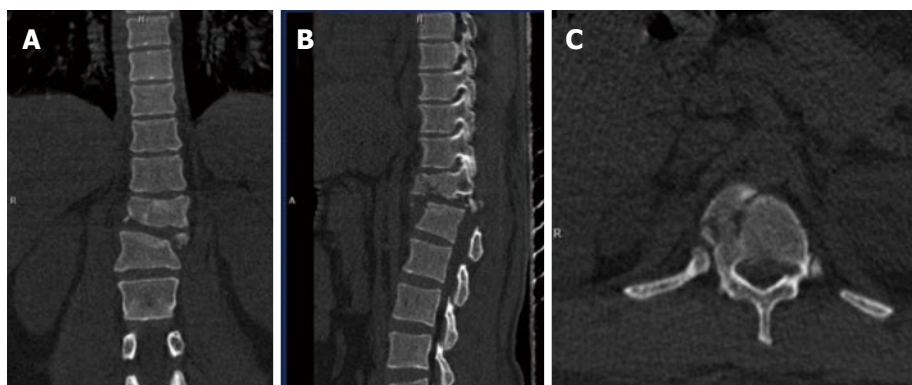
Type C1 rotational injuries. Coronal computed tomography (CT) reformat (A), sagittal CT reformat (B) and axial CT images (C) show C1 injury where rotation is superimposed on a type A injury.
